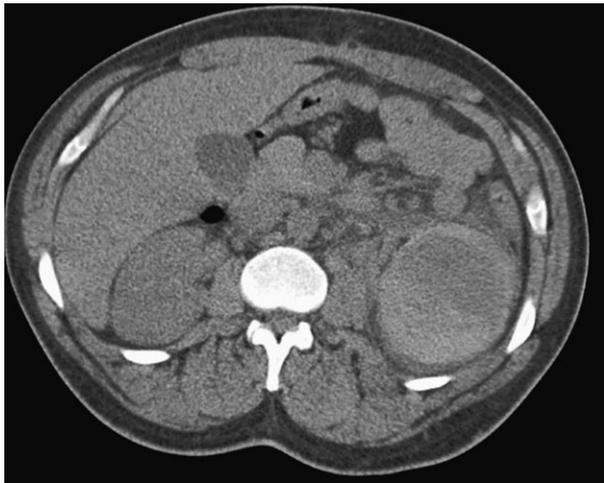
CT Abdomen: left perinephric hematoma.
